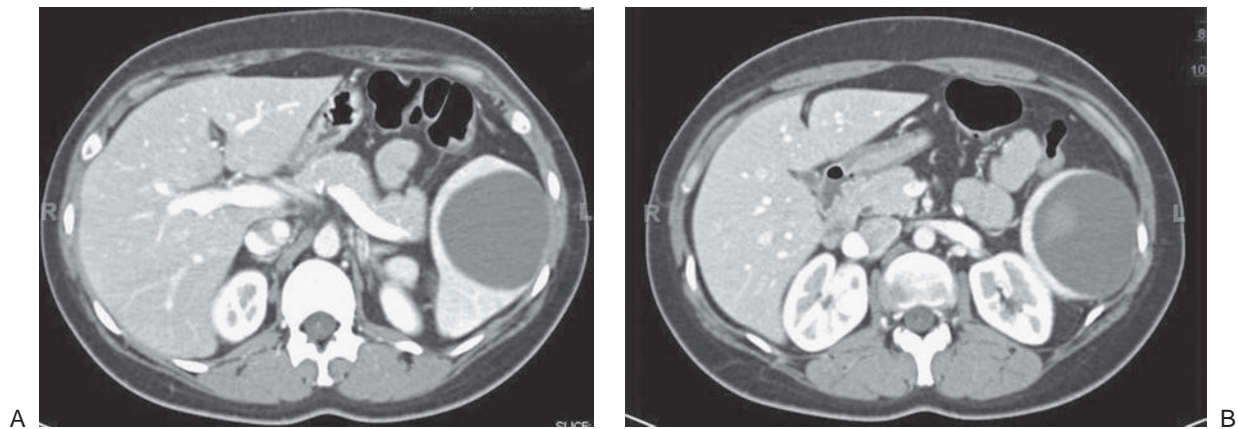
A: CT of a 43-year-old woman who was scanned after developing left upper quadrant pain. She had no history of trauma. CT showed a splenic pseudocyst. B: After aspiration, some blood is seen in the cyst lumen. The cyst rapidly reaccumulated, and the patient subsequently had a successful laparoscopic cyst deroofing.
